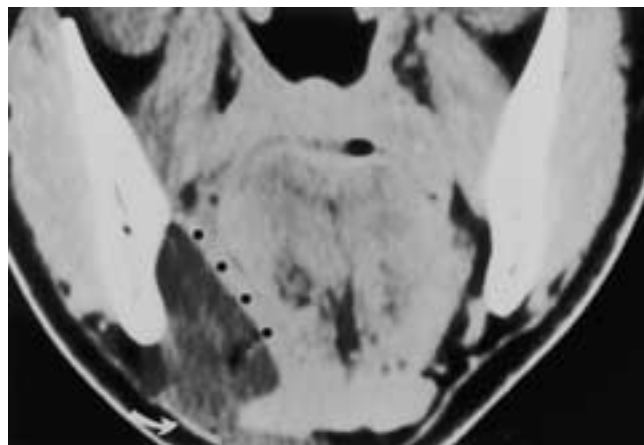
Lymphangioma. Coronal contrast-enhanced CT scan demonstrates a lymphangioma in the right submandibular space elevating and displacing the right mylohyoid muscle (*black dots*). The lesion is contained by fibers of the platysma muscle (*white arrow*).
